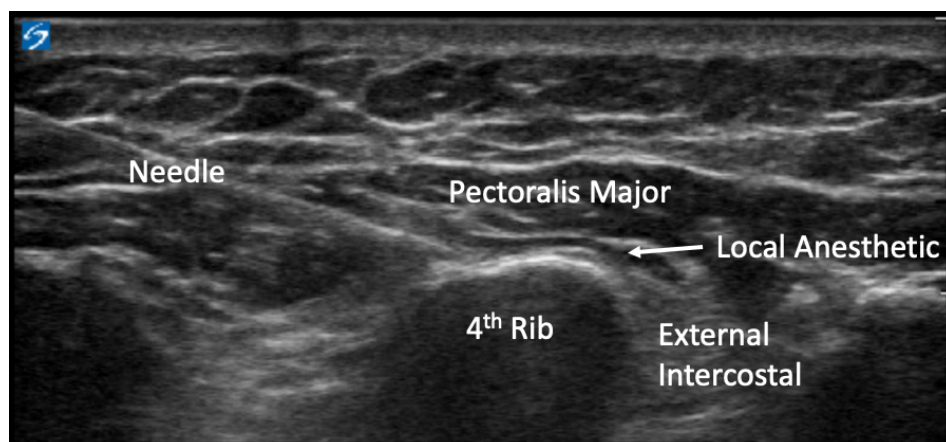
Superficial parasternal block by ultrasound at level of 4<sup>th</sup> rib.
